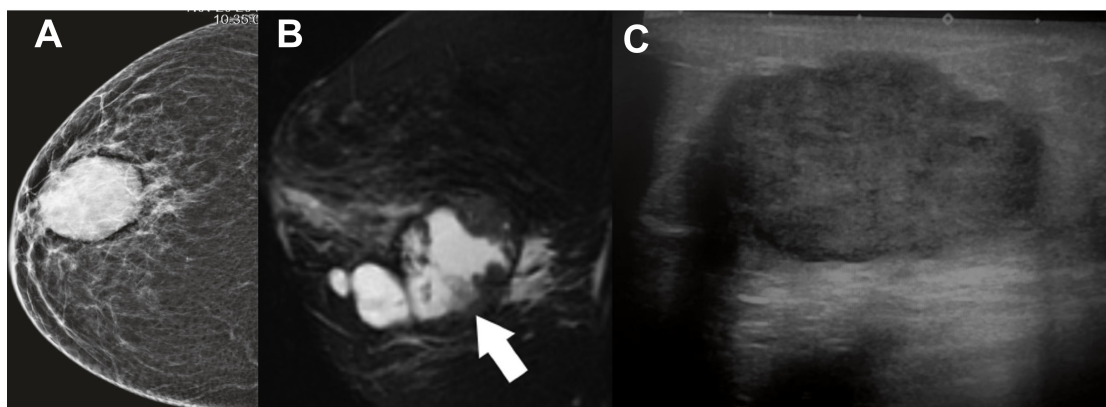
Imaging features of Triple Negative subtype. A) circumscribed oval mass is on MG, B) a round mass with rim enhancement is observed on MRI, and C) on US reveals hypoechoic and round mass.
